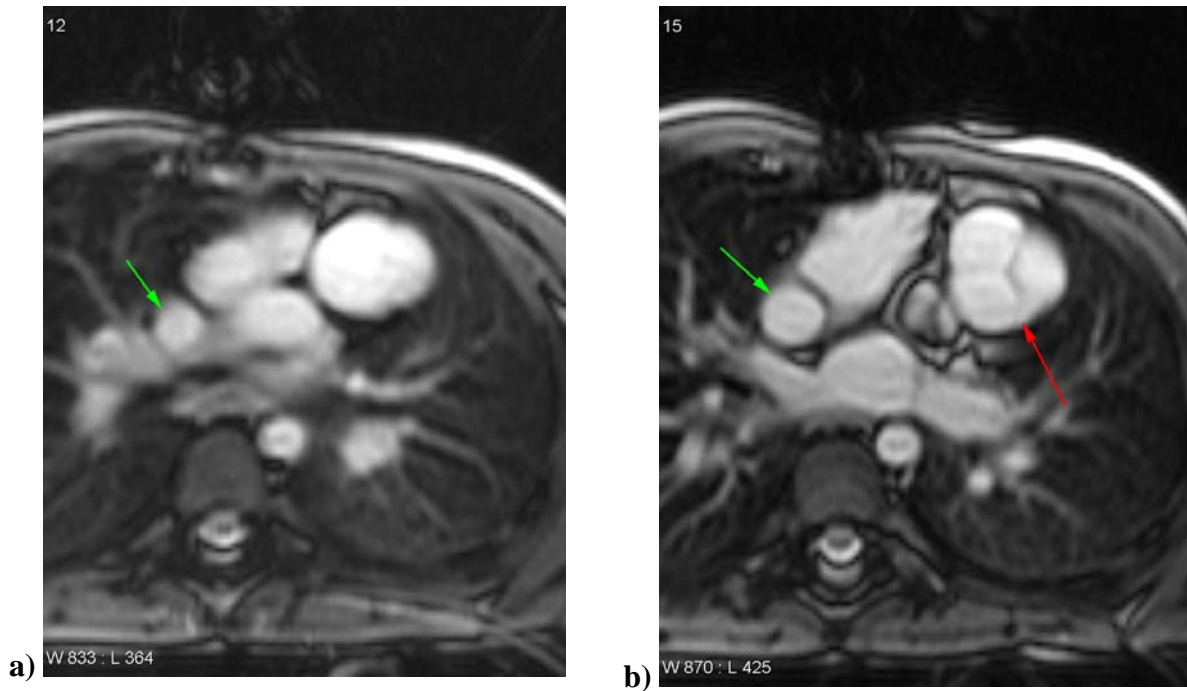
MRI of lateral tunnel baffle (green arrow) at the a) anastomosis site on the inferior side of the right pulmonary artery and location of the b) aortic valve (red).
